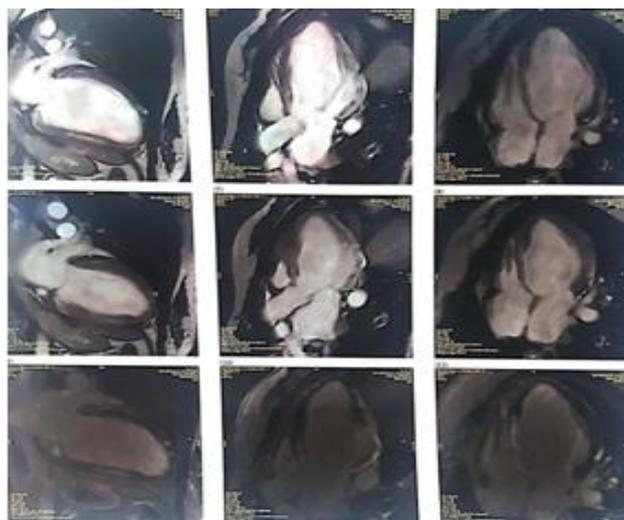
Cardiac MRI documented a late enhancement related to a dense fibrosis in epicardial muscle.
